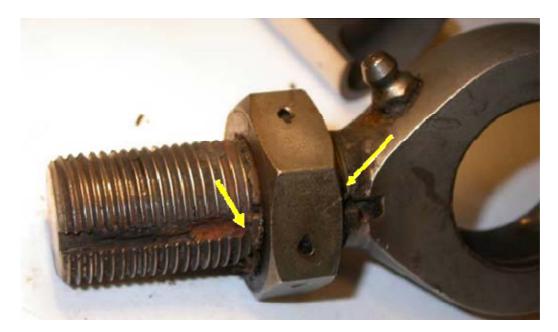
Sampling points for energy dispersive x-ray analysis.
